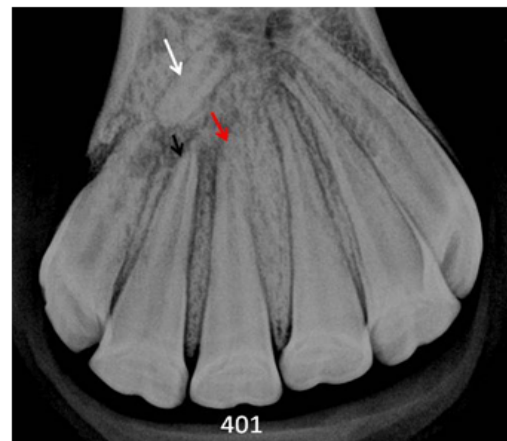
This radiograph was taken Feb. 10, 2010 showing the apical parts of 401 and 402 have now been resorped (red and black arrows) and the apical fragment of 403 is nearly homogenous in opacity. On the radiograph the fragment (white arrow) is projected axially due to oblique projection.
